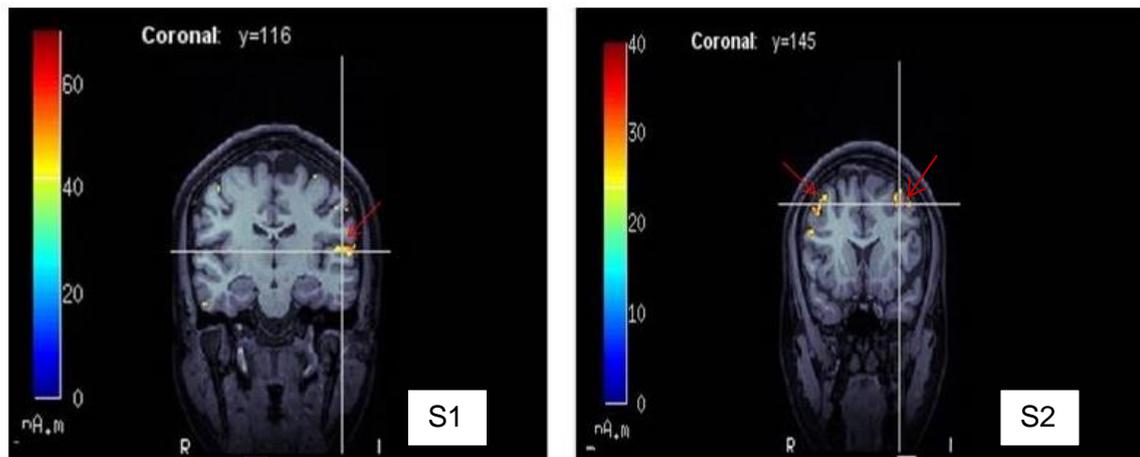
wMNE (imposed on individual MRI coronal view) areas of activation in individual participant at their peak latency amplitude during S1(STG) and S2(IFG) condition (colour bar represents strength of source activation, red = strong, blue = weak)
